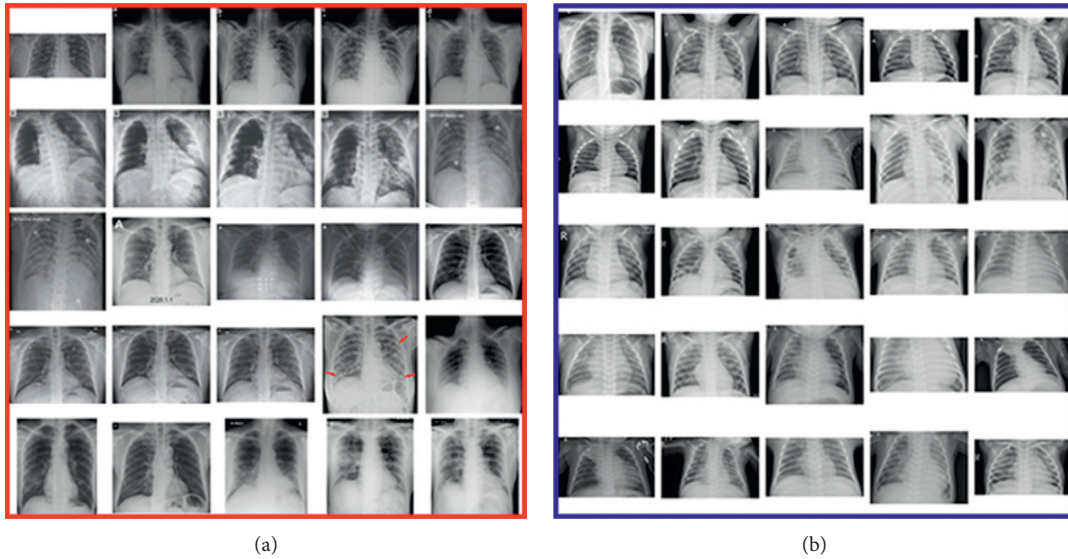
Chest X-ray image dataset: (a) normal persons' X-ray images, i.e., COVID-19 (-); (b) COVID-19-infected patients' X-ray images, i.e., COVID-19 (+).
